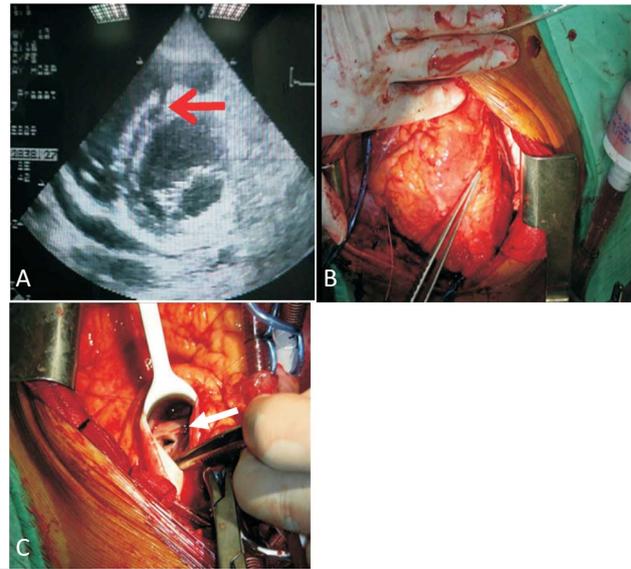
(A) Possible ventricular septal defect at 11 o'clock direction in parasternal short-axis view. (B) 2 cm fibrotic change scar over right ventricular wall, which was 1 cm away from pulmonary annulus. (C) Traumatic ventricular septal rupture about 2×1 cm in size at right ventricular outflow tract (RVOT).
